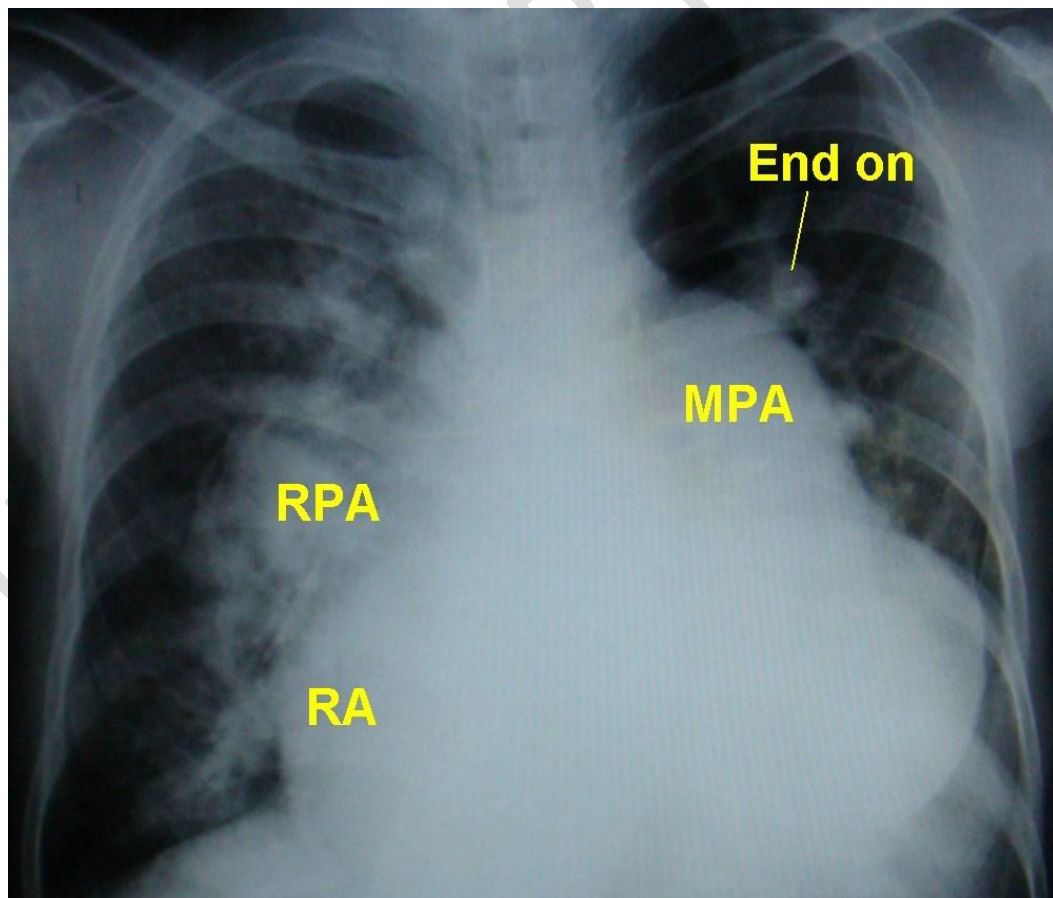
this chest X-ray in ASD shows grossly dilated main pulmonary artery (16)
